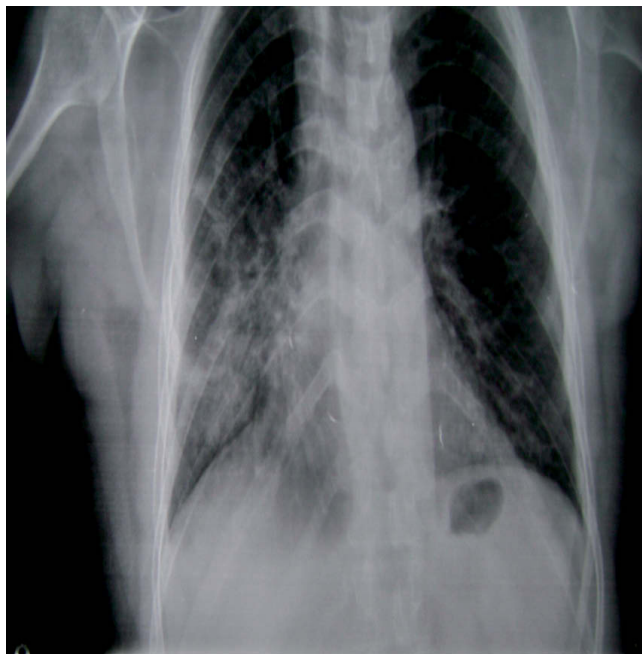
Case 2. Antero-posterior chest X-ray: bilateral alveolar-interstitial infiltrates, more pronounced in the right lung, with inflammatory lesions in the lower and middle lobes.
